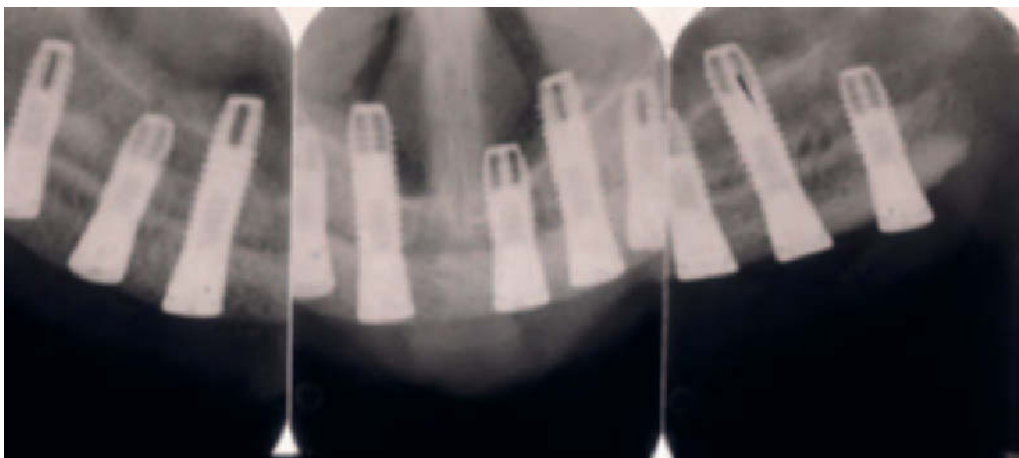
Radiograph of bone graft and implants.
